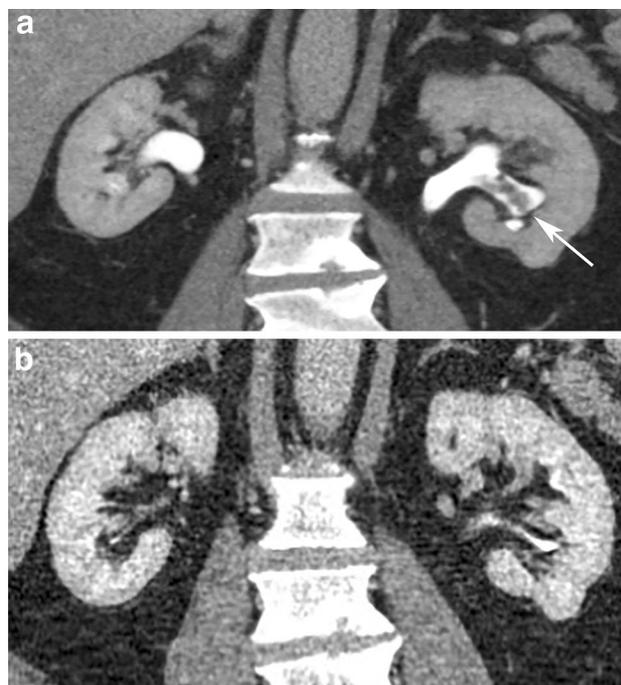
Mucus. a A coronal reformatted excretory phase contrast-enhanced CT image through the kidneys in a patient who had undergone cystectomy and an ileal loop urinary diversion shows an irregular filling defect in a left lower pole calyx and infundibulum (arrow). This filling defect was non-enhancing. The non-enhancing nature of this filling defect led the urologist to decide to follow the lesion with imaging. b On this coronal reformatted excretory phase contrast-enhanced image from a repeat CT obtained 5 months later, the filling defect was no longer present
